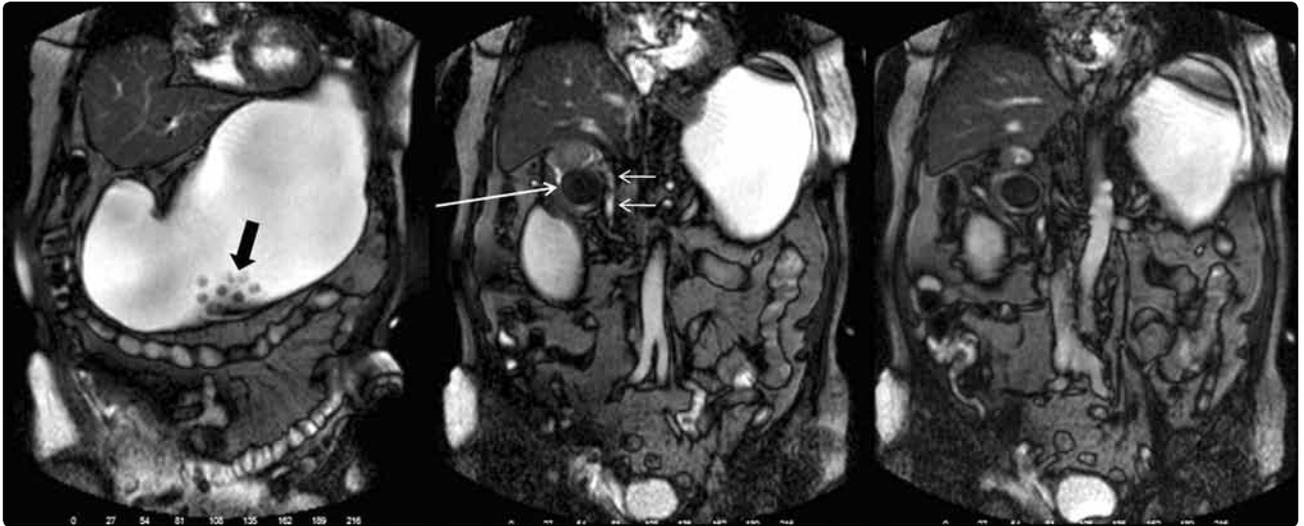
Sequential coronal non-contrast-enhanced MRCP images show multiple gastric stones (thick arrow) and a large calculus impacted in the gastric pylorus (long arrow). There are several T2-weighted hypointensities in the ductus choledochus (short thin arrows).
